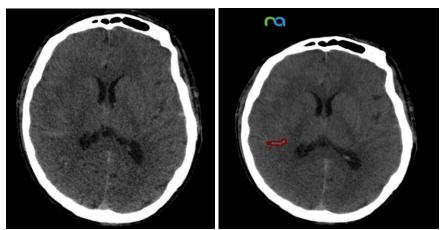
Al algorithm (NeuralAssist, TeleradTech) demonstrating a small right convexity sulcus subarachnoid hemorrhage on a noncontrast CT scan of the brain performed in the setting of trauma.
